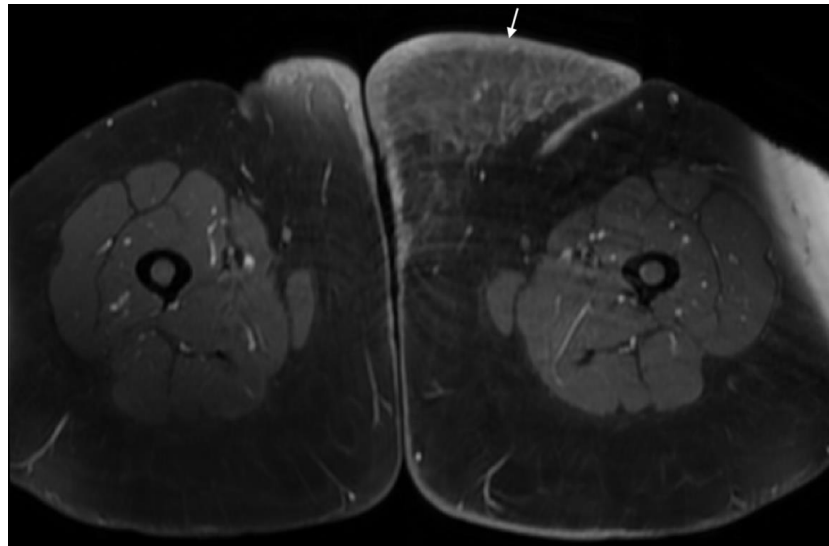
Axial T1-weighted MRI image with contrast enhancement, showing the skin thickening (white arrow)
